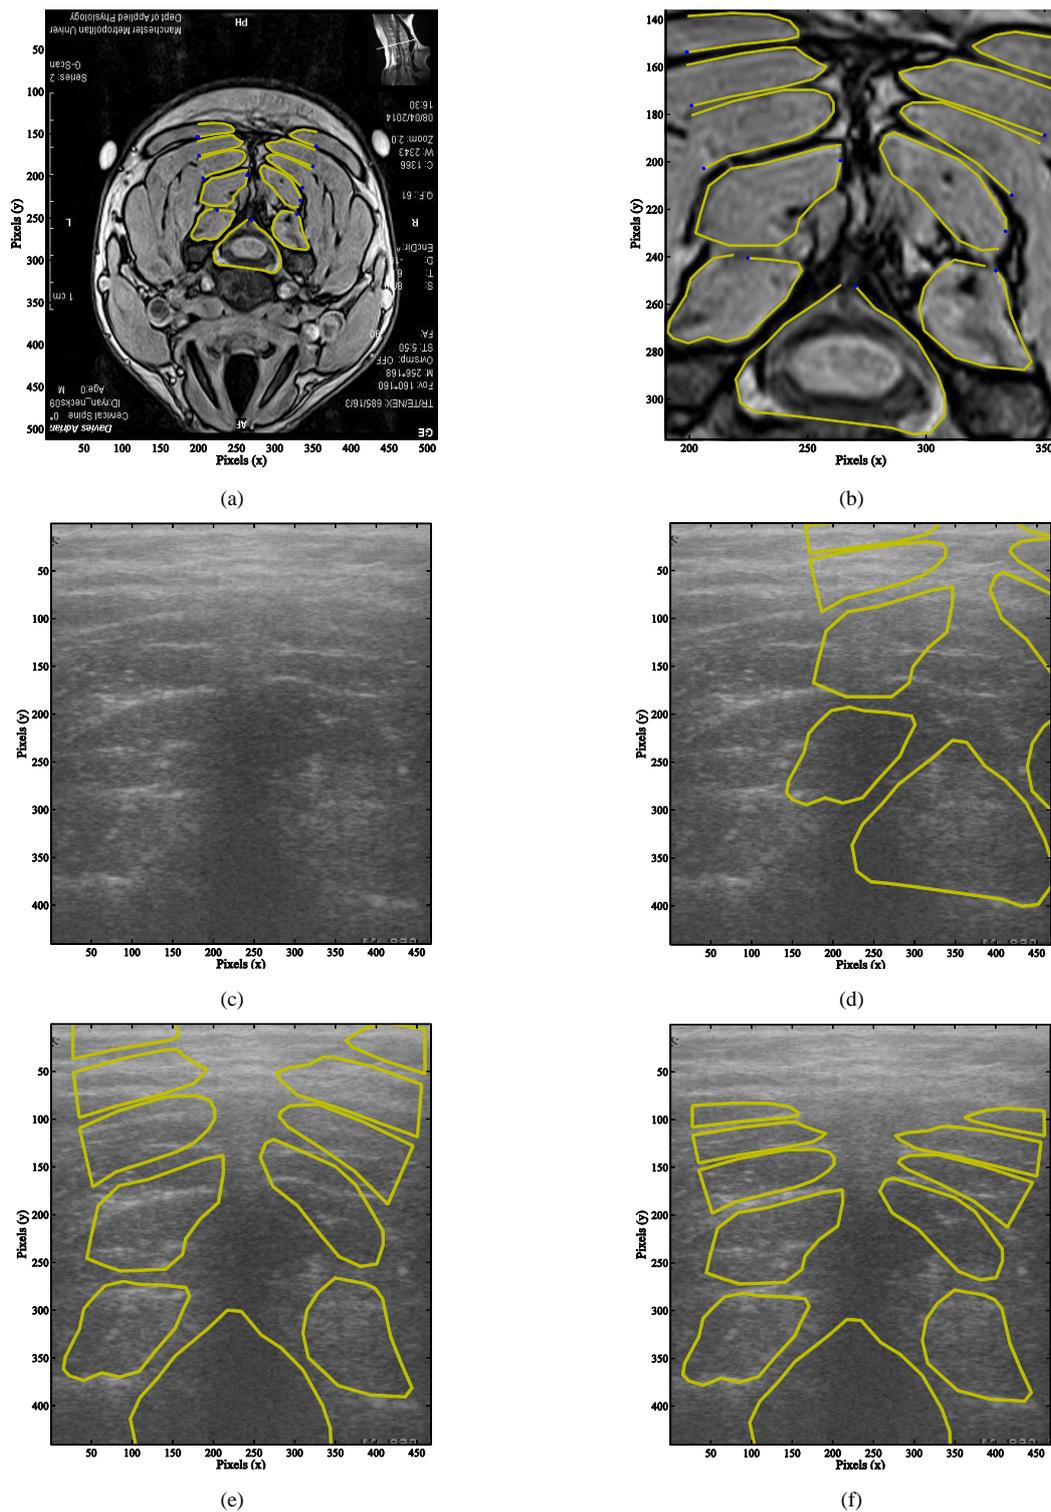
Human expert contour registration process: (a) and (b) expert-marked contour overlays a participant's neck MRI image. (c) participant's corresponding neck ultrasound image. (d) MRI contours scaled to the metric dimensions of ultrasound image. (e) expert translates and rotates the MRI contours to best match deep muscle boundary gradients. (f) expert applies contour squashing function (Equation 10) to match ultrasound image gradients.
